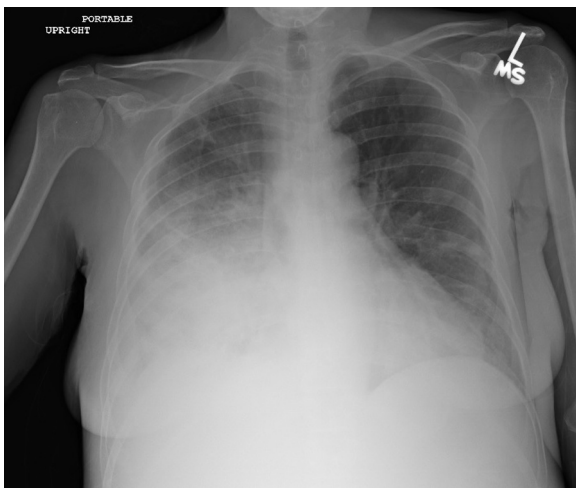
Anteroposterior chest x-ray study demonstrating multifocal pneumonia and a right pleural effusion.
